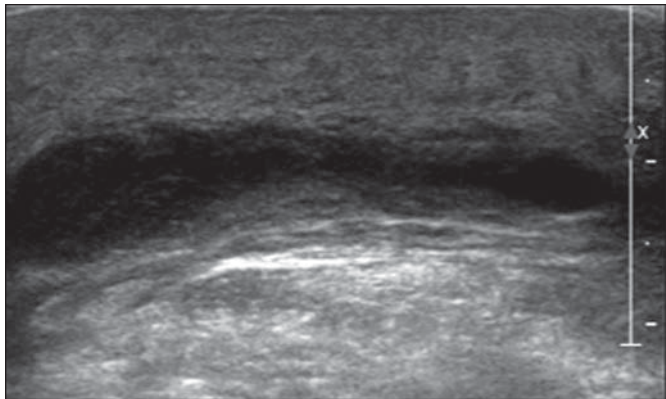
19-year-old man with infected fluid collection due to infectious prepatellar bursitis. Gray-scale ultrasound image shows few internal echoes within prepatellar bursa. Minimal complexity may be secondary to synovitis or infection. Aspiration revealed infectious bursitis despite only minimal complexity of fluid.
